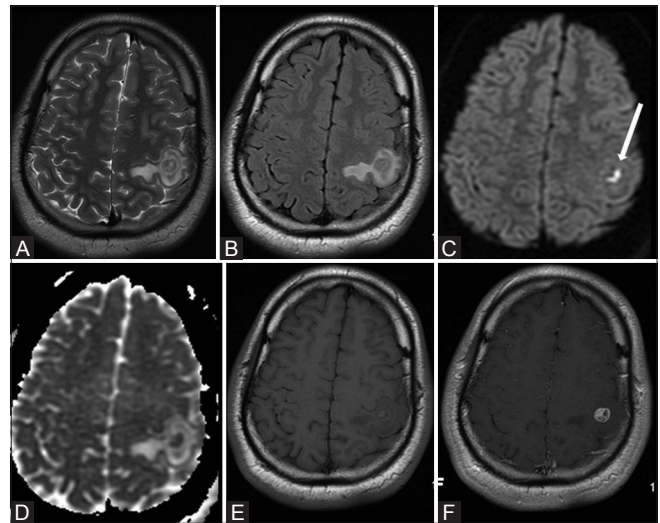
(A-F): Subsequent MRI brain with and without contrast in case 1 shows a ring configuration with perilesional edema expanding the left post central gyrus on T2 and FLAIR images (A and B). Small area of restricted diffusion (C and D; white arrow in C) and T1 shortening (E) is seen within this lesion. Post contrast T1 image shows an irregular crenated thick-walled round rim enhancement (F)
